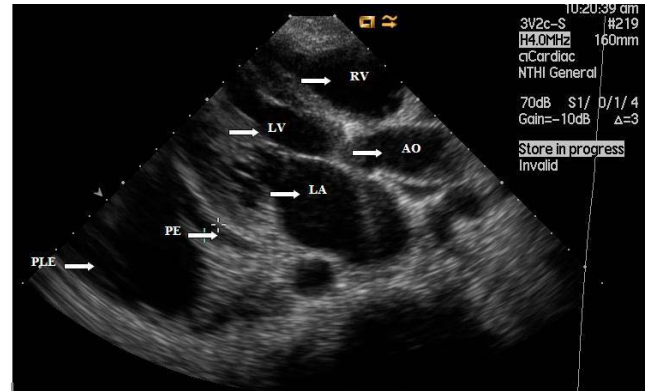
echocardiography, Parasternal view
